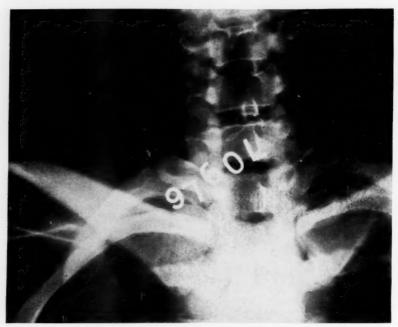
Case 2: Roentgenogram showing short bilateral cervical ribs; the larger one is on the right, but neither articulates with the first rib. The reproduction is rather indistinct but shows well on the original roentgenogram.
